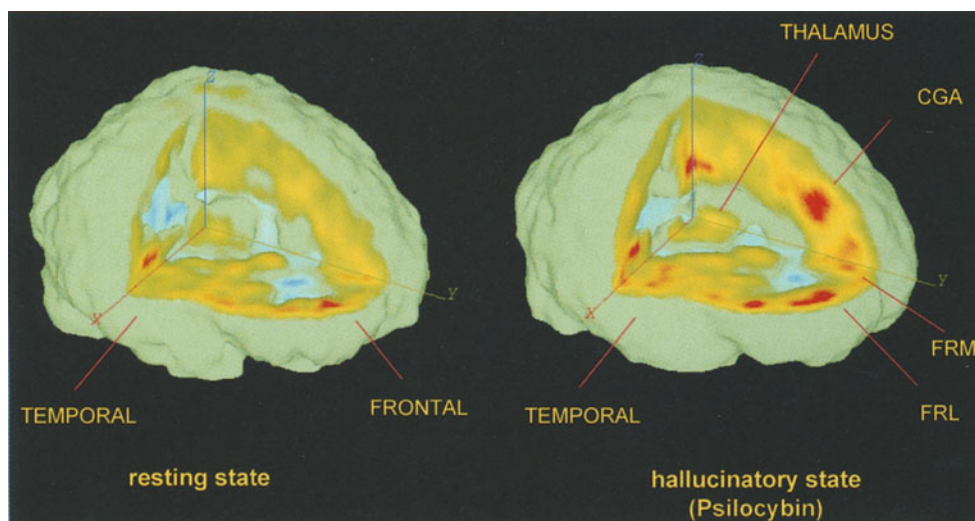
Fluorodeoxyglucose ($[^{18}\text{F}]\text{FDG}$) positron emission tomography (PET) images under baseline conditions (*left*) and after psilocybin challenge (*right*). CGA, cingulate gyrus; FRM, medial frontal cortex; FRL, lateral frontal cortex. (After Vollenweider et al. 1997)
